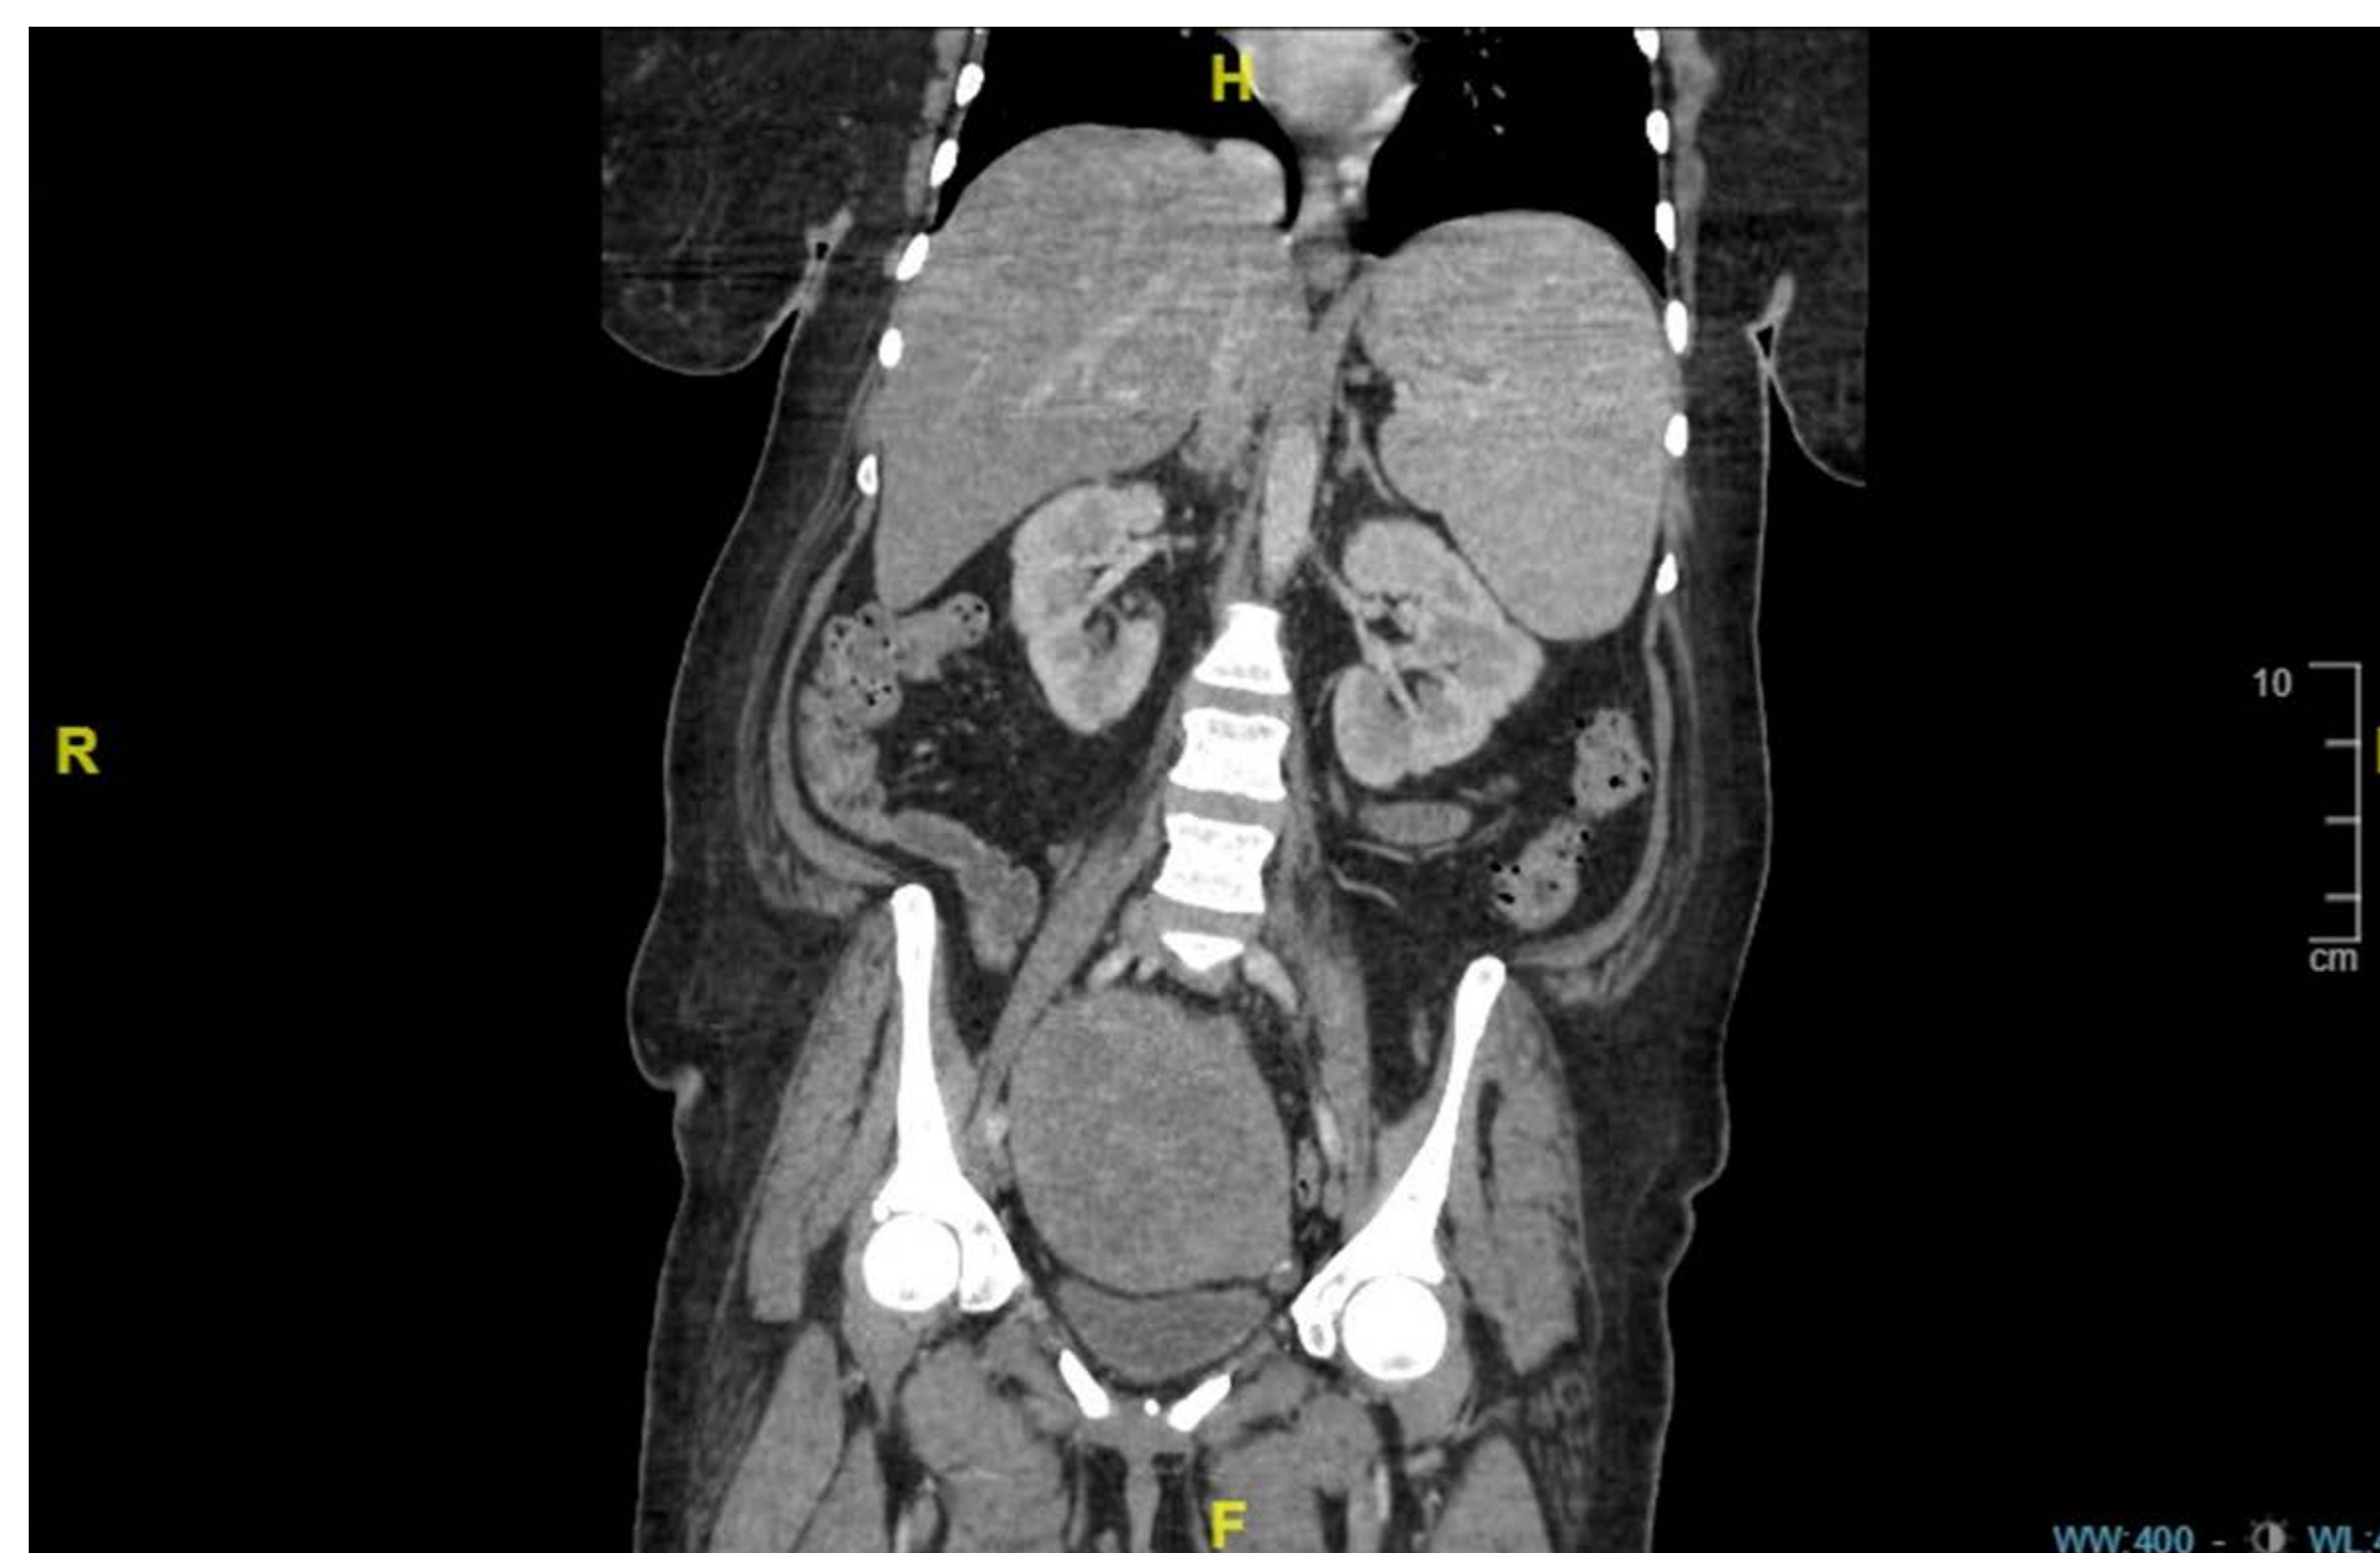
CT abdomen w/o contrast: splenomegaly and hepatomegaly
